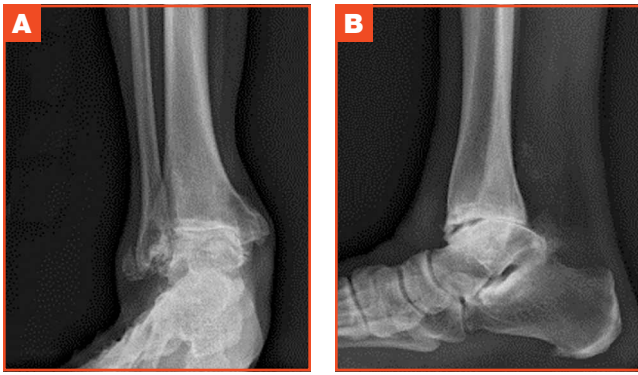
Case 1: (A) Anteroposterior and (B) lateral radiographs showing extensive arthritic change to the ankle with posterior subluxation to the talus.
